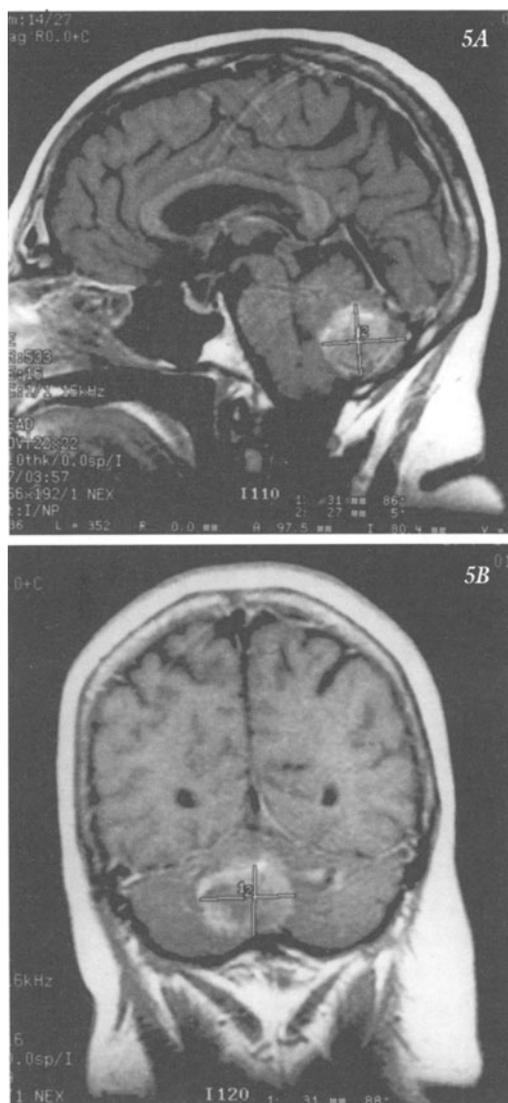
Metastatic midline cerebellar tumor: Case 20-2. MRI (T1) a) sagittal section b) coronal section. Refer to text.
